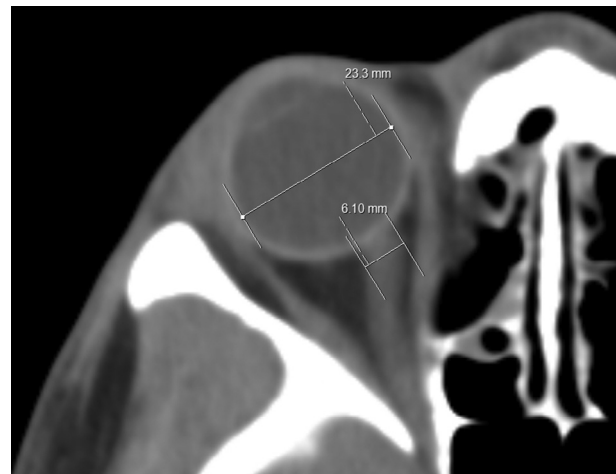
Axial computed tomography scan showing how optic nerve sheath diameter and eyeball transverse diameter measurements were obtained.
